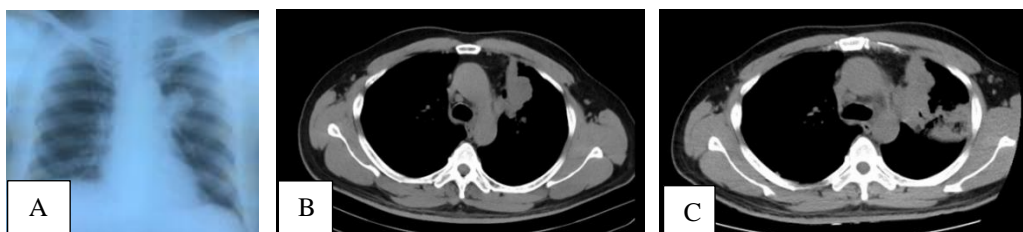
(A). Chest X-Ray prior to nodules biopsy, (B). Chest CT Scan following (A) (C). Chest CT Scan prior to diagnostic bronchoscopy procedure
